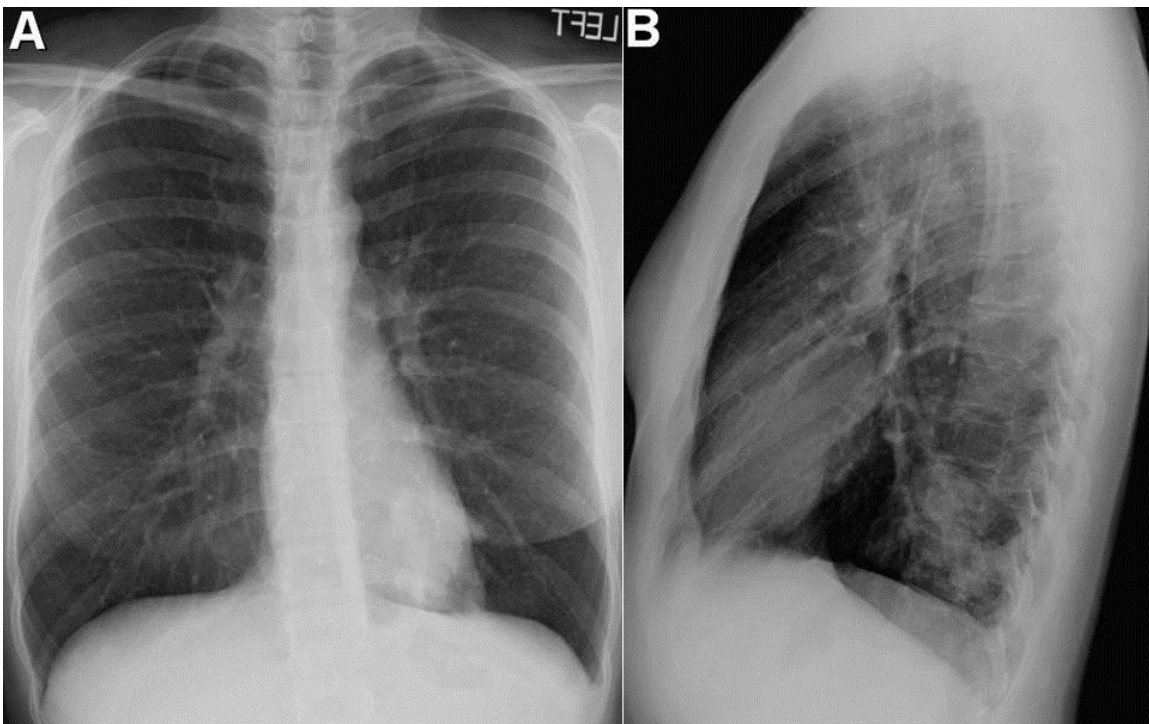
Frontal (Panel A) and lateral (Panel B) chest x-ray.
